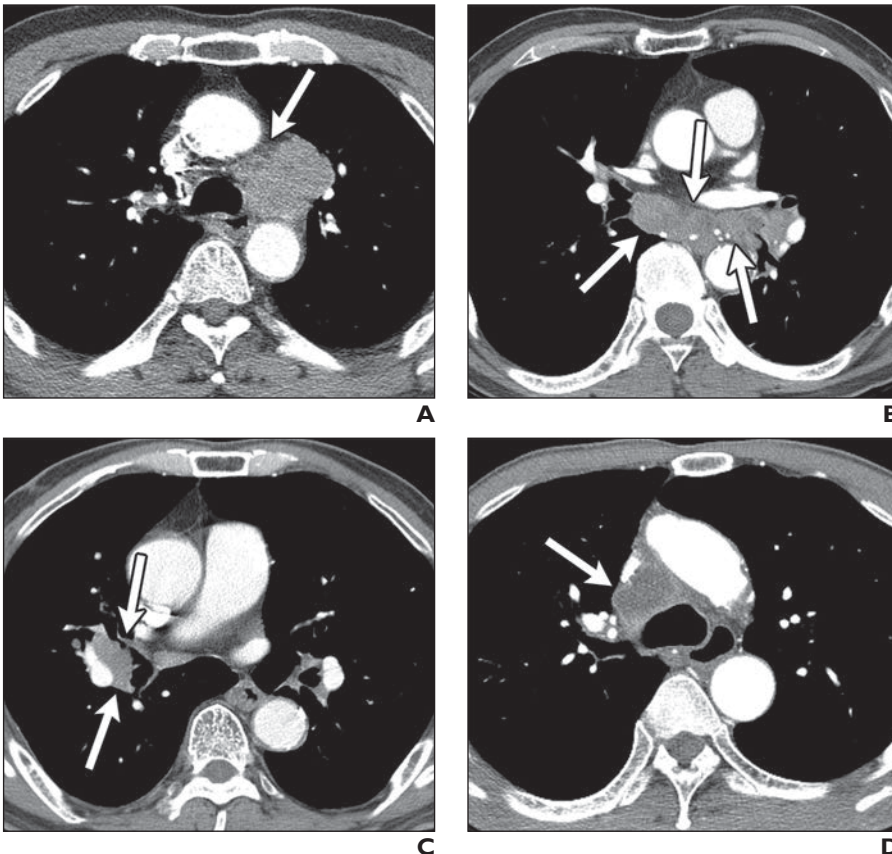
Axial images from contrast-enhanced staging chest CT examinations in four patients with non-small cell lung cancer show representative examples of binary features assessed as possible predictors of extranodal extension.
